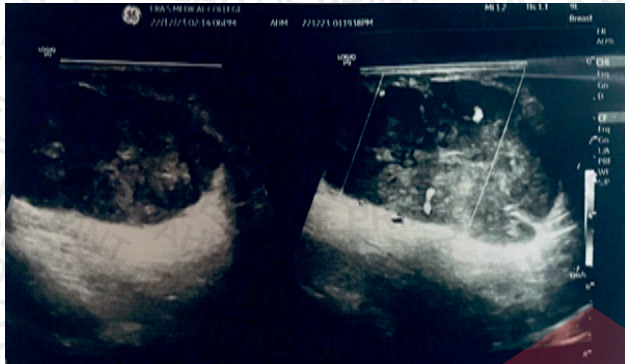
Ultrasonography showed well defined lobulated heteroechoic space occupying lesion with significant internal vascularity in left chest wall likely BIRADS IV/V.
